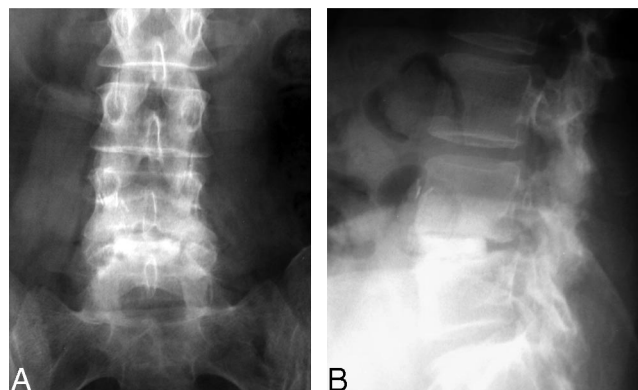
In contrast, aggressive bone resorption and bone graft disintegration were unusual in radiographs of pseudarthrosis after ALIF with FRA and autogenous ICBG (A, B). Note how the FRA is still structurally intact at 12 months.
